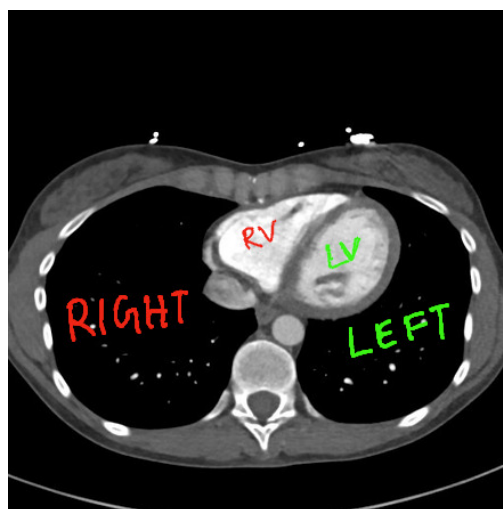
CT radiology annotated to observe real body orientation.
